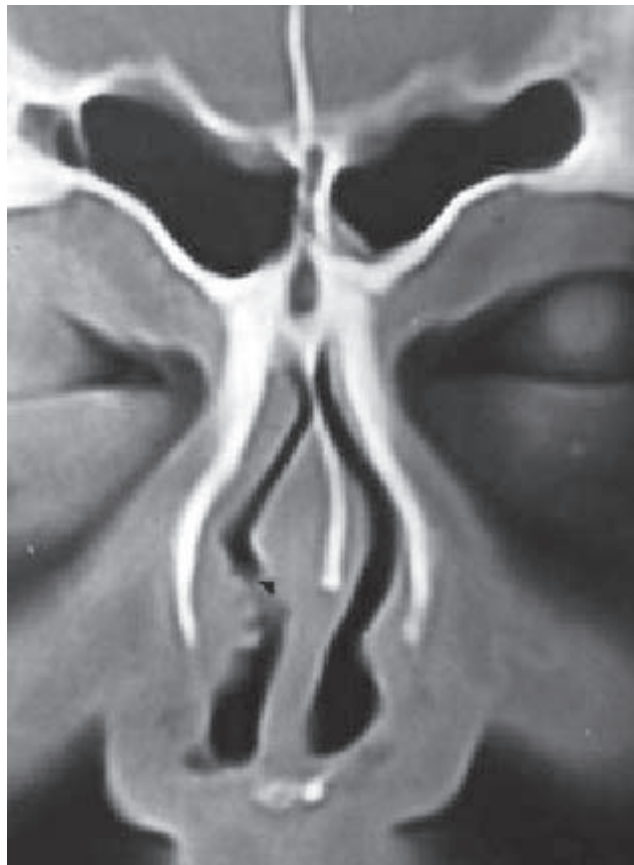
CT scan shows thickening of the septal mucosa on the left side (arrowhead).
